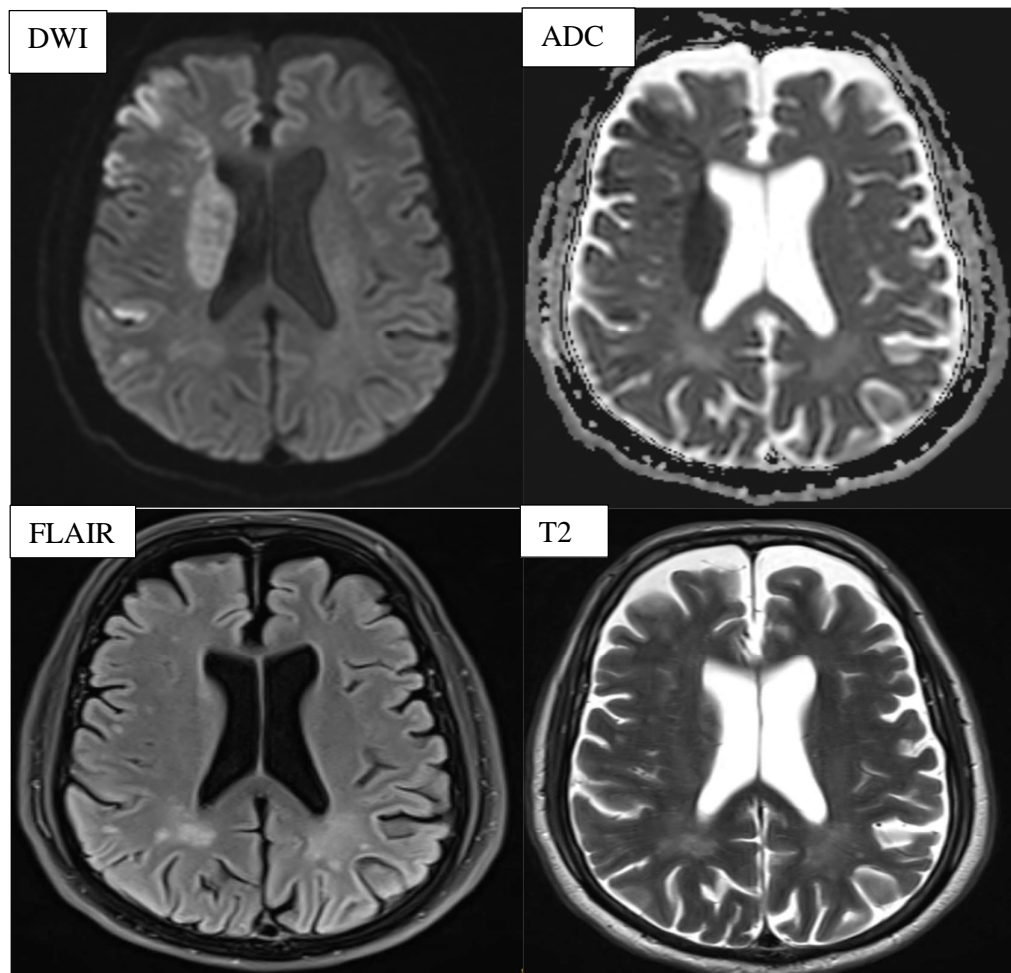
INFARCT IN RIGHT MCA TERRITORY SHOWING DIFFUSION RESTRICTION; HOWEVER FLAIR AND T2 WEIGHTED IMAGING SHOWING NO ALTERED SIGNAL INTENSITY – ‘DWI-FLAIR MISMATCH’
